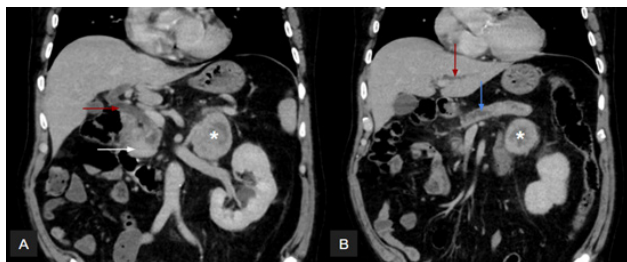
Abdominal venous phase CT coronal images showing bile duct dilation (extra and intrahepatic) (red arrows), as well as dilation of the main pancreatic duct (blue arrow in B) caused by a hypervascular pancreaticoduodenal lesion (white arrow). A lesion in the left adrenal gland can also be seen (white asterisks).
